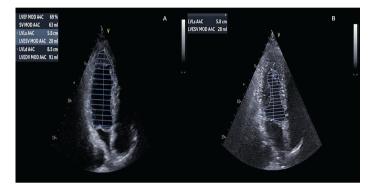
Transthoracic echocardiography of the patient after coronary angiography
